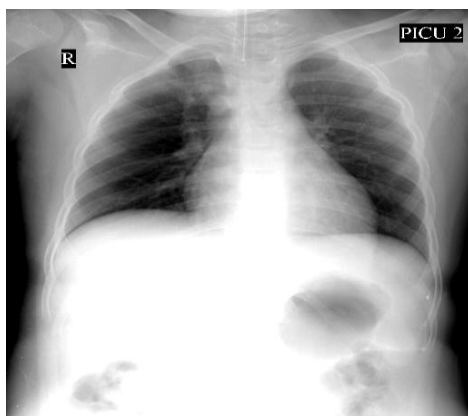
Chest X-Ray without abnormal findings
